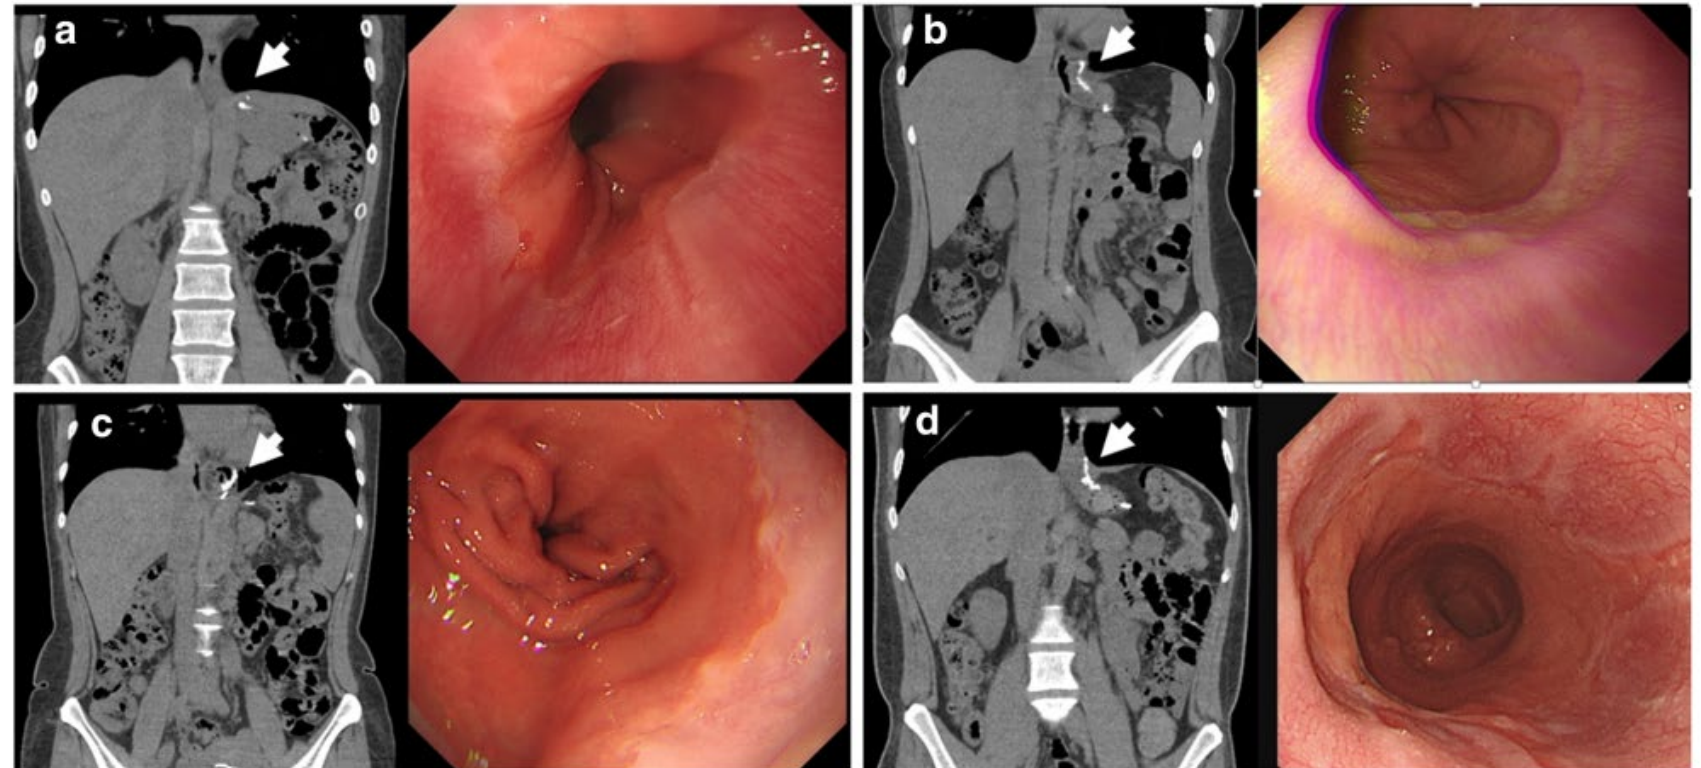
ITSM was defined as the presence of staple lines (arrows) above diaphragmatic crus in coronal CT view. a ITSM (-). b-d ITSM (+)
